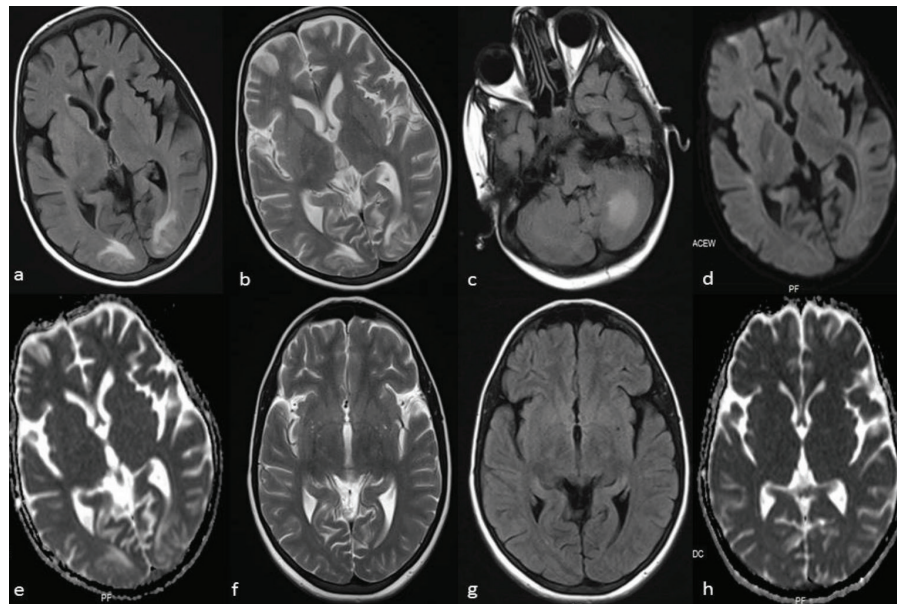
16-year old girl after liver transplantation (patient 9). Axial MR images a. (T2-weighted) and b. and c. (fluid-attenuated inversion recovery) demonstrate edema in the occipital lobes and cerebellum. Diffusion-weighted images d. with b-1000 and e. with apparent diffusion coefficient (ADC) demonstrate increased diffusion in the occipital lobes. After 3 months of treatment, axial MR images f. and g. and ADC h. show normal findings.
